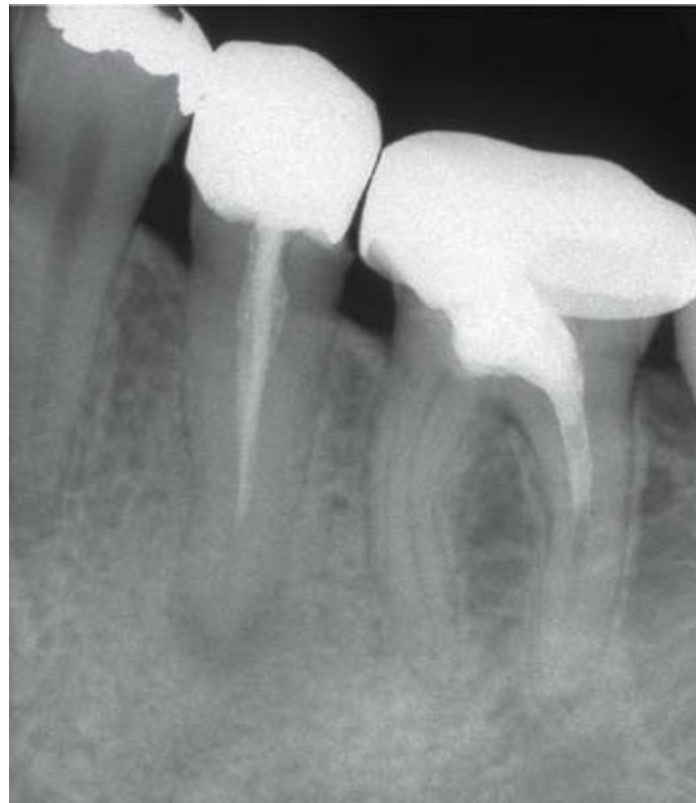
A periapical radiograph of a mandibular left second premolar
